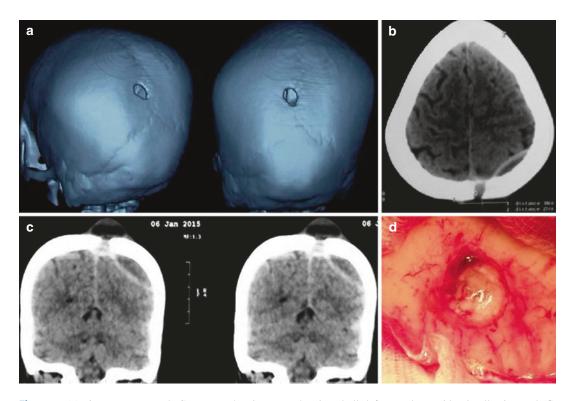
(a) 3D reconstructed CT scan showing a punched-out lesion involving both tables of the skull in a 40-year-old lady (lytic tuberculosis) almost near the midline, (b, c) coronal and axial CT images with contrast
